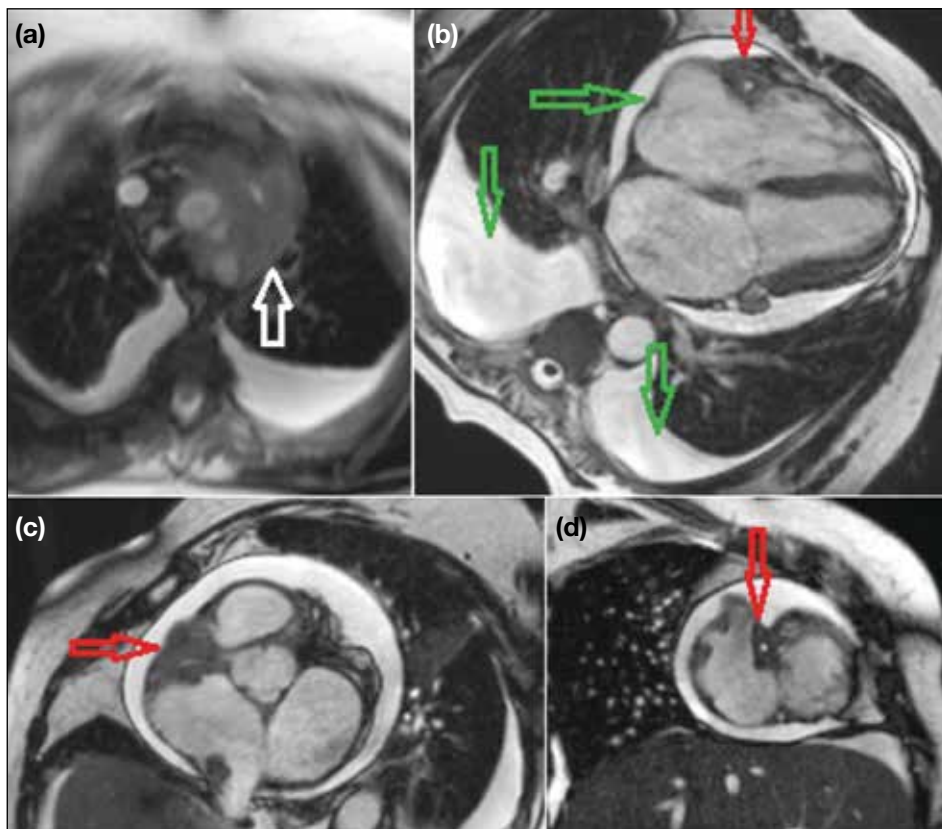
Cardiac magnetic resonance imaging of a 74-year-old female patient with a diagnosis of mediastinal lymphoma (white arrow in [a]). (b-d) Images showing lymphoma infiltration around right coronary artery and its branches (red arrows). Pericardial and bilateral pleural effusions were also noted (green arrows in [b]).
